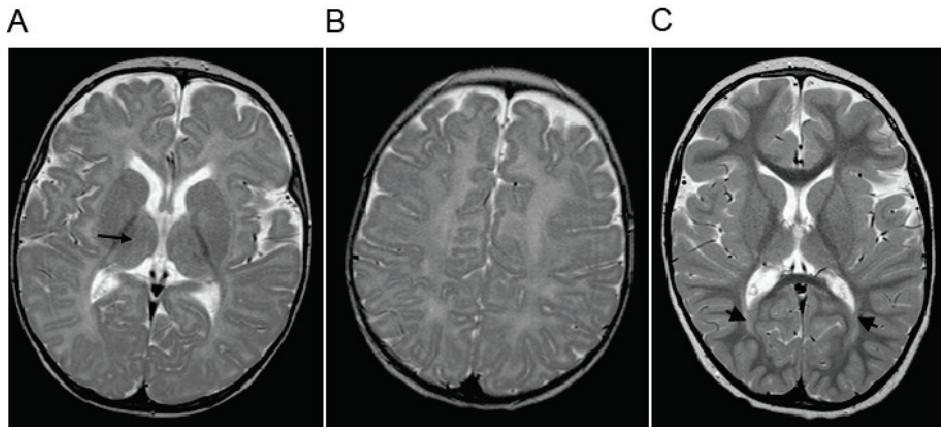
Brain MRI findings of two affected individuals with *UBA5* variants. (A and B) T2-weighted MR images of affected individual A-6 at the age of 6 months. Myelination is delayed and there is slight signal increase in thalami (arrow). (C) T2-weighted MR image of affected individual A-4 at the age of 5 years. There is signal increase periventricularly (arrows) and thalami are mildly atrophic. Myelination is appropriate for age.
